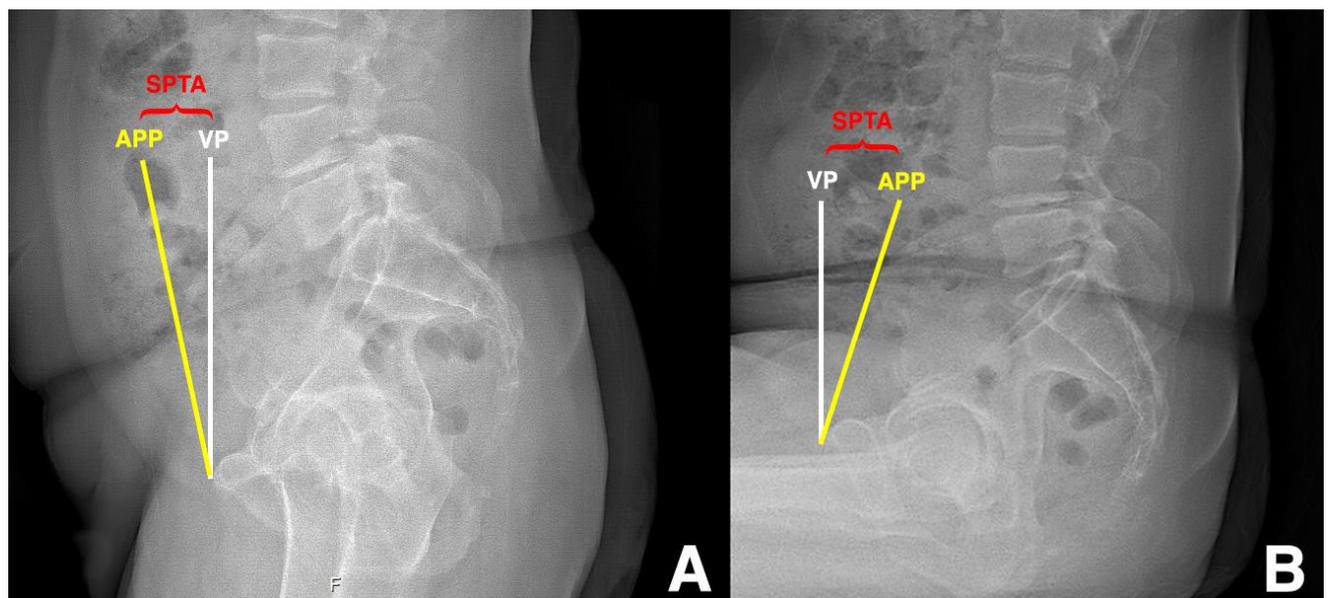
Preoperative sagittal pelvic tilt angle (SPTA) measurements standing (A) and sitting (B) lateral pelvic radiographs. SPTA, sagittal pelvic tilt angle between the anterior pelvic plane (APP, yellow line connecting the antero-superior iliac spines to the pubis) and the vertical plane (VP, white line). There is anterior sagittal pelvic tilt relative to the VP in standing, and there is posterior sagittal pelvic tilt in sitting.
